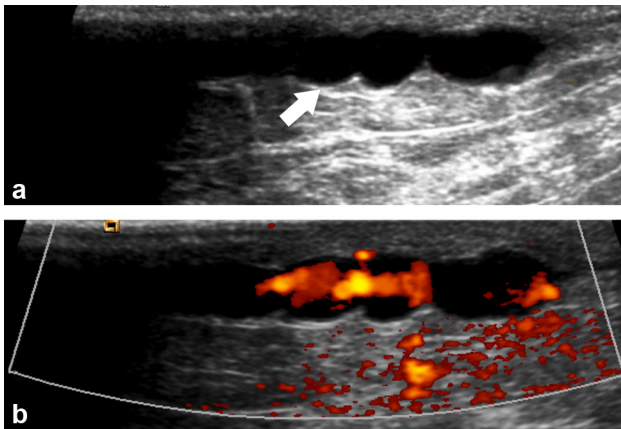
A 59-year-old woman with recently diagnosed ductal carcinoma *in situ* of the right breast. (a) Cropped grayscale ultrasound image demonstrates a dilated non-compressible periareolar superficial vein (arrow); (b) Cropped grayscale ultrasound image with power Doppler applied demonstrates decreased internal flow compatible with superficial thrombophlebitis or Mondor disease.
